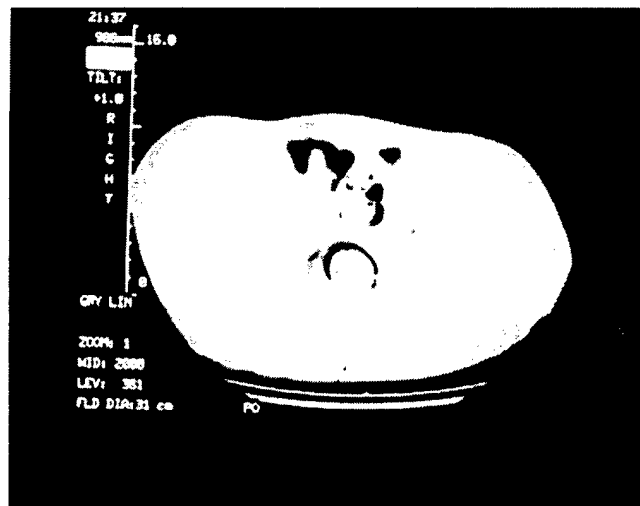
CT scan demonstrating effusion and further destructive changes. Hardware appears to be entering the joint. Other CT images suggested a healed fracture.
